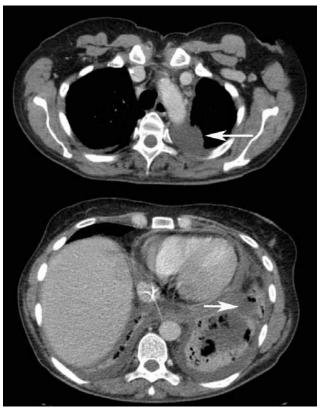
CT scan of chest demonstrating collapse of the left lung and effusions in the left pleural cavity (arrows).
